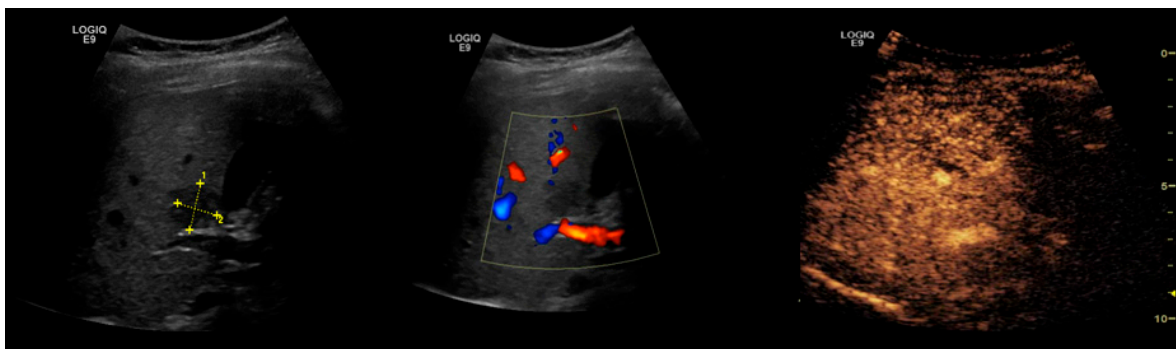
Focal sparing in the pericholecystic region. Hypoechoic image located around the gallbladder in a fatty liver. The Doppler examination cannot reveal any vessels within the lesion. On CEUS, the enhancement was homogeneous during the arterial, portal, and parenchymal phases, without any apparent focal lesions.
